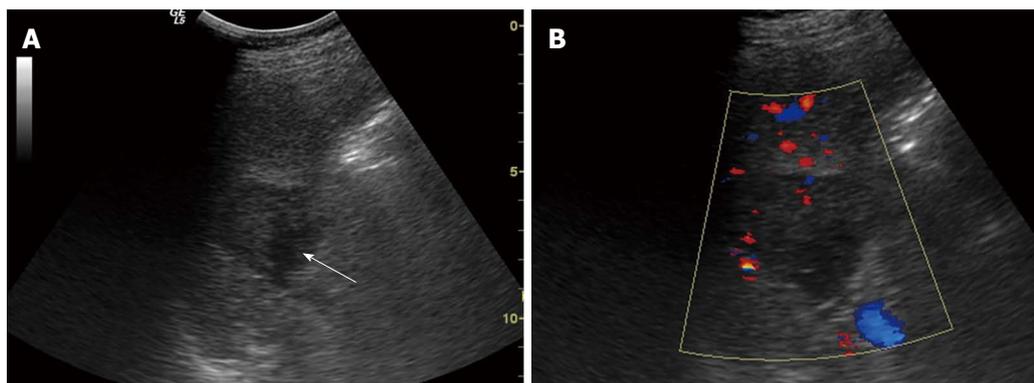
Conventional sonographic findings of sclerosing angiomatoid nodular transformation in a 36-year-old man. A: B mode ultrasonography demonstrates a hypoechoic lesion (arrow) in the spleen; B: Color Doppler flow imaging shows a low color-flow signal in the lesion.
